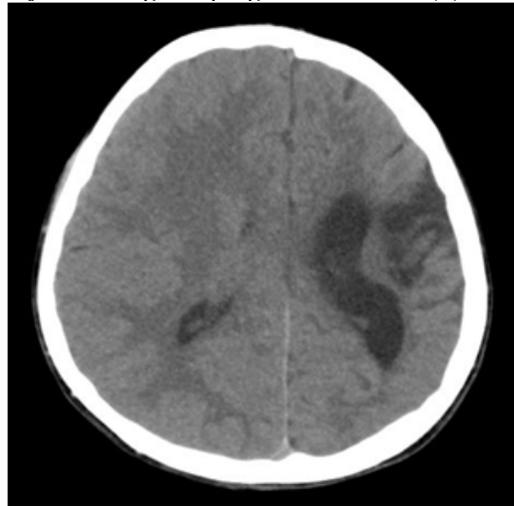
plain CT showing Old infarct with gliosis in left fronto-parietal regions with resultant exvacuo dilatation of ipsilateral lateral ventricle. . Hyper-pneumatization of left frontal sinus.Mild hypoplasia of left petrous apex.
